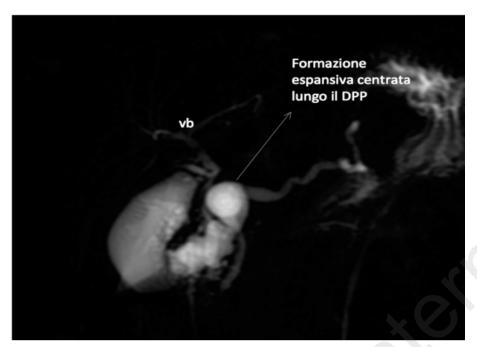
MR image. Sagittal projection shows the cystic lesion.
